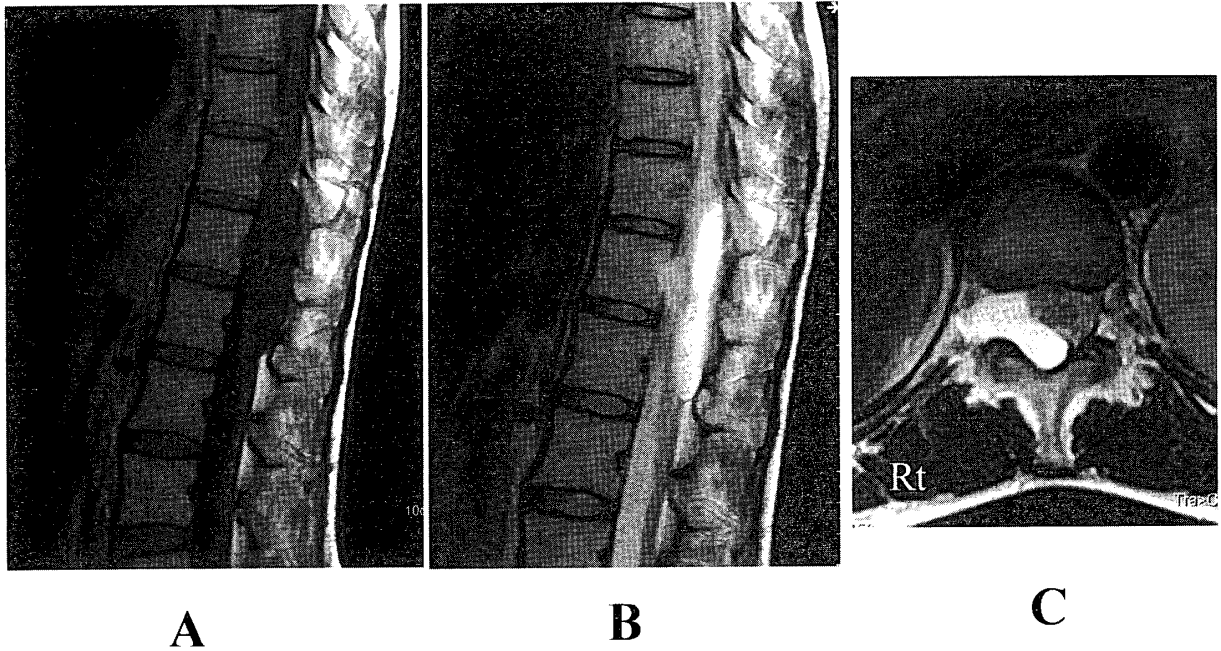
Sagittal T1 (A) magnetic resonance imaging (MRI) and sagittal(B) and axial T2 (C) MRI showed an extradural CSF-containing lesion without involvement of the posterior epidural fat at Th11-L1.
